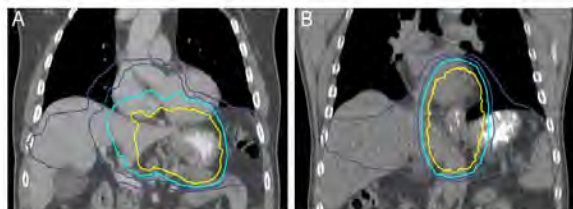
Examples of pre-treatment planning CT scans with dose distributions in (A) a patient who developed postoperative anastomotic leakage after receiving a mean dose to the gastric fundus of 41.2 Gy, and in (B) a patient who did not experience postoperative anastomotic leakage after receiving a mean dose to the gastric fundus of 11.8 Gy. The areas within the yellow, light blue, dark blue and purple lines received at least 40, 30, 20, and 10 Gy, respectively.
